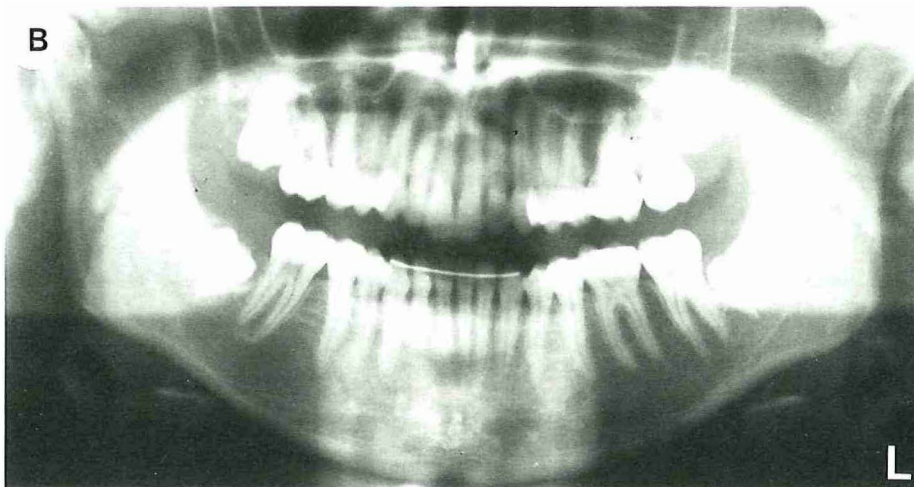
A Orthopantomogram of a 10-year-old girl showing secondary retention of the mandibular right first molar. B Orthopantomogram of the same patient 6 years after removal of the retained molar and its antagonist. The diastemas in both the maxilla and mandible were closed by orthodontic treatment.
